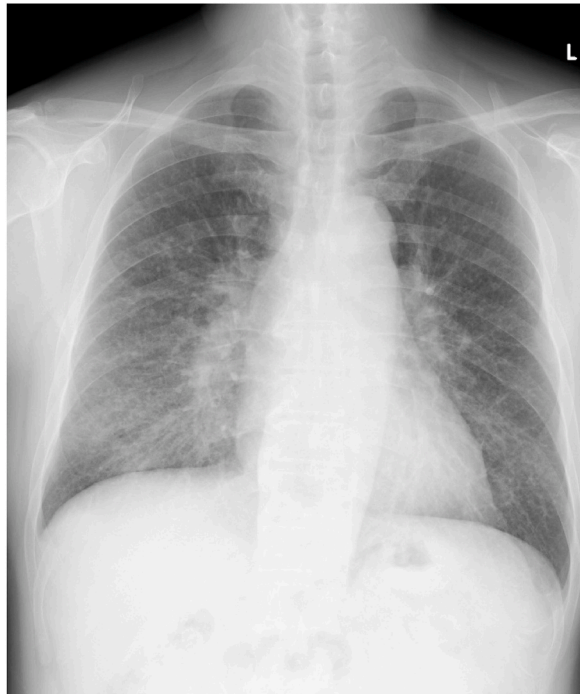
Chest X-ray on the patient's first visit shows mild infiltration in the bilateral middle and lower lung fields.
